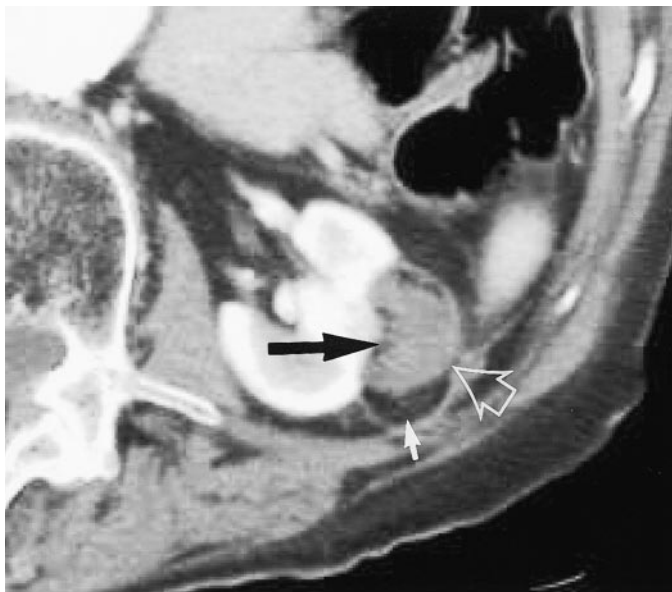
Patient 5. Large exophytic renal cell carcinoma with progression of CT findings after RF ablation in an 85-year-old woman. (a) Left: Transverse contrast-enhanced CT scan shows an enhancing 3.4-cm renal cell carcinoma (arrow) of the left kidney. Right: Transverse contrast-enhanced CT scan obtained at a similar level within 1 month after repeat RF ablation shows no enhancement, a decrease in the size of the anterior component of the renal cell carcinoma (short arrow), and persistent enhancement of the posterior component (long arrow). At a more inferiorly transverse level (not shown), the renal cell carcinoma showed no enhancement. The patient was re-treated, with the enhancing region targeted. (b) Transverse nonenhanced (left) and contrast-enhanced (right) CT scans obtained after the second visit show no residual tumor enhancement (arrows). (c) Transverse contrast-enhanced CT scan obtained 6 months after the second visit shows a further decrease in the size of the renal cell carcinoma (open arrow), no enhancement, and encapsulated fat (solid white arrow) in the region previously occupied by tumor, as well as fat (black arrow) at the interface of the renal cell carcinoma and the normal kidney.
